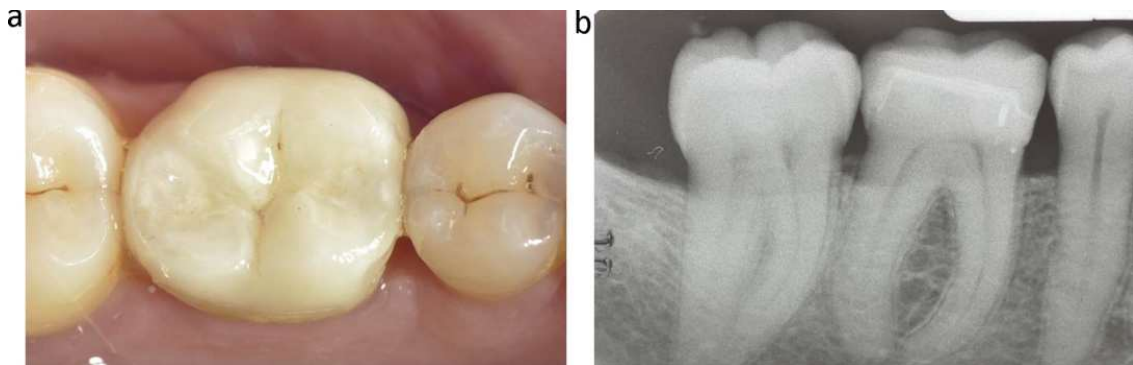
a, b. Recall after 12 months; clinical and radiographic views.
